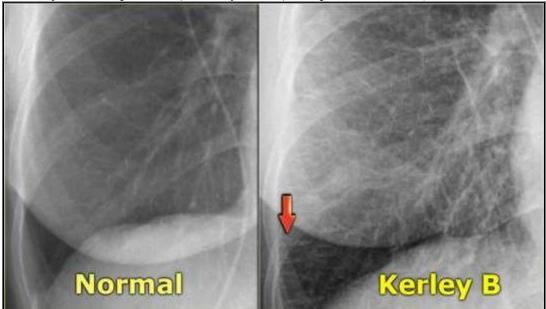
Kerley-B lines are seen as peripheral short 1-2 cm horizontal lines near the costophrenic angles. Echocardiography:
